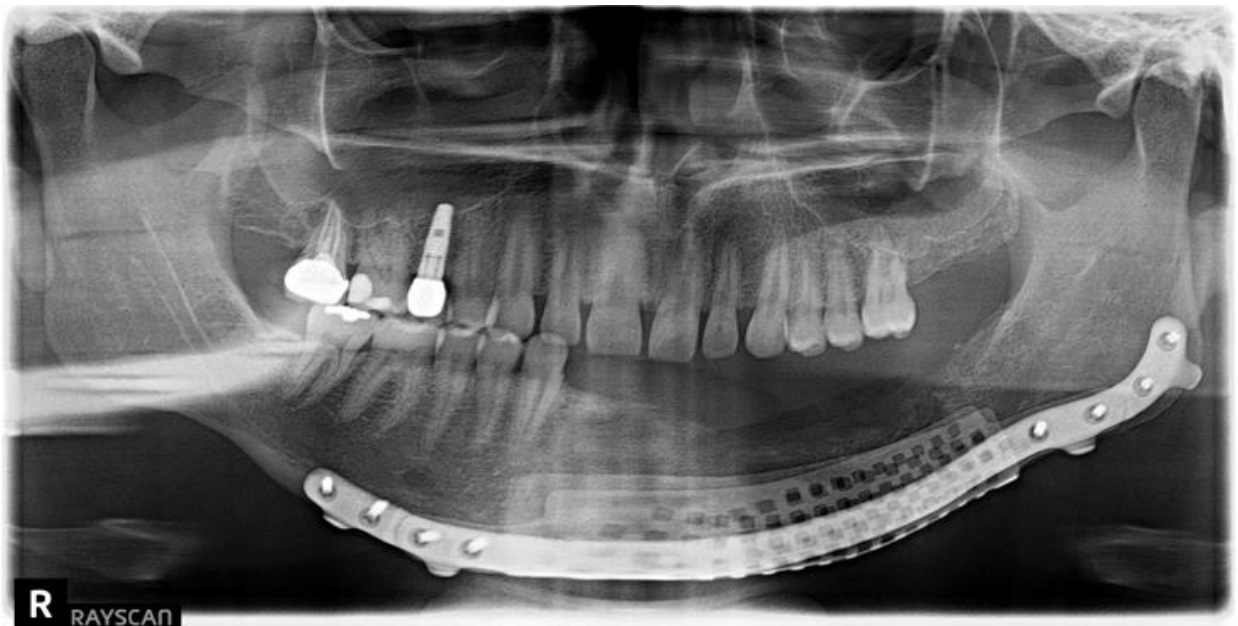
Post-operative panoramic radiograph following debridement of infected graft.
